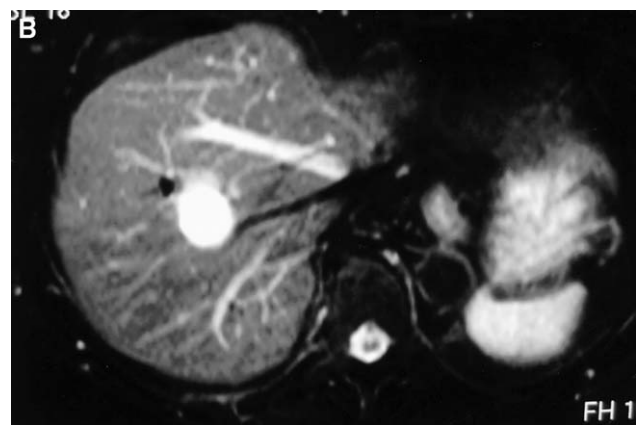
Magnetic resonance imaging shows (A) a low-signal lesion between the middle and right hepatic veins on T1 and (B) a high-intensity signal on T2.
